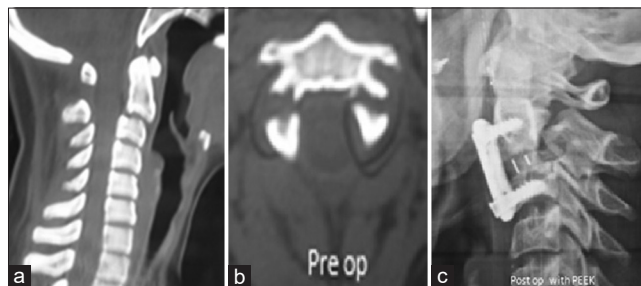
(a) Lateral cervical spine X-ray showing Levine Edward Type 2 unstable hangman's fracture with listhesis. (b) Axial computed tomography scan of cervical spine showing bilateral pars fracture of the C2 in the same patient. (c) Lateral cervical spine X-ray showing anterior cervical discectomy and fusion done at C2–C3 level
